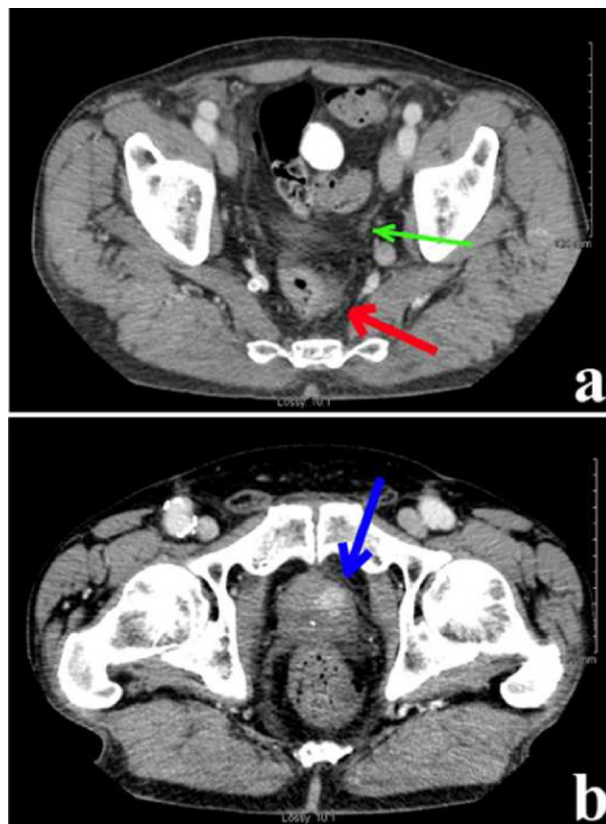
Staging CT scan images demonstrate (a) the cranial edge of the rectal primary (red arrow), a suspicious perirectal lymph node (green arrow), and (b) contrast enhancement within the prostate (blue arrow).
